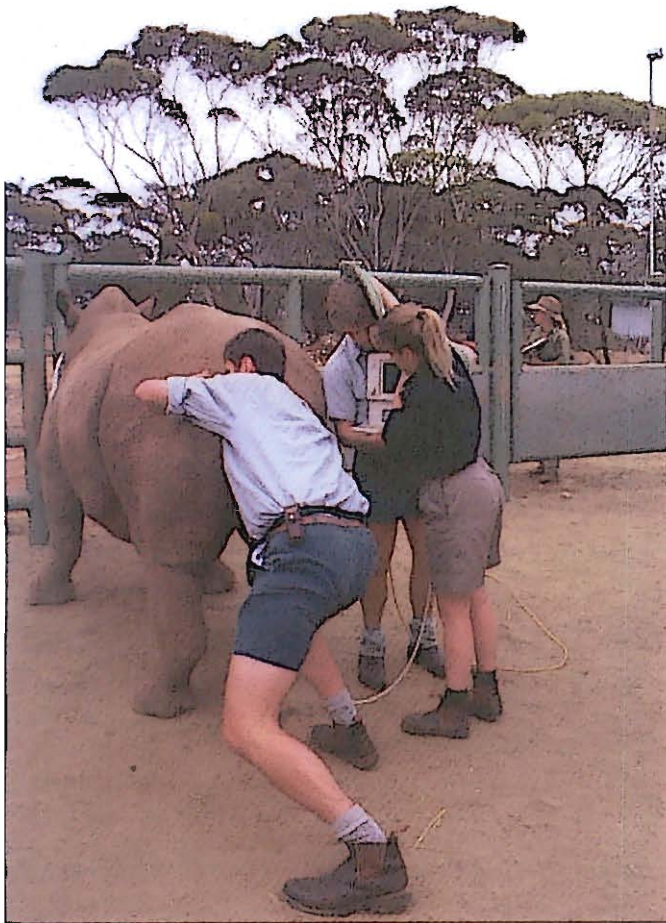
Standing sedation in an adult, female, white rhino to facilitate transrectal ultrasonography for pregnancy diagnosis.
